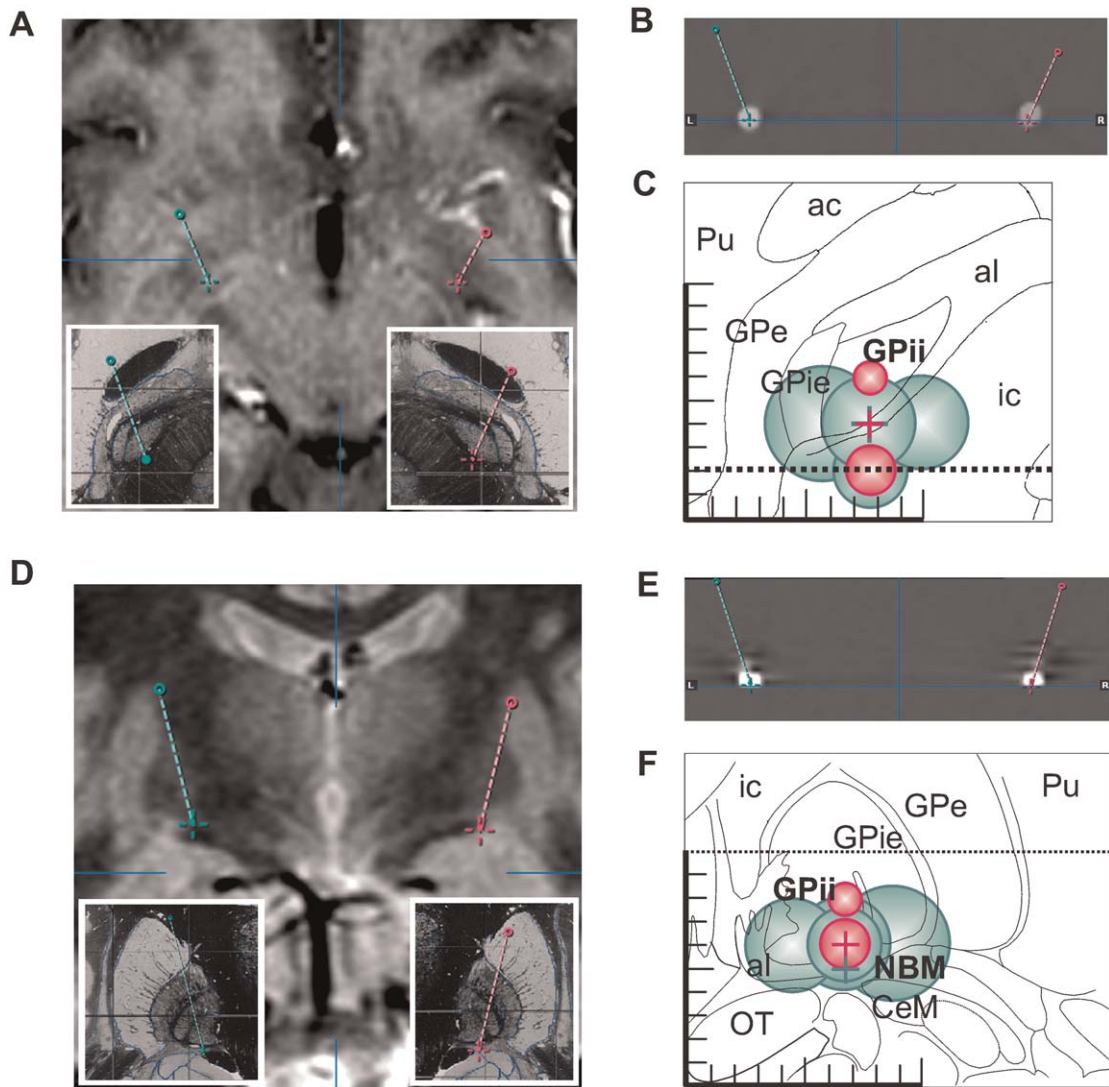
Stereotactic reconstruction. Stereotactic reconstruction of stimulation sites in the horizontal (A–C) and frontal plane (D–F), respectively. (A) Horizontal T1-weighted MR section with planned target sites at the pallidal base. Insets show the trajectory superimposed on corresponding horizontal sections of the Schaltenbrand/Bailey atlas (Schaltenbrand and Bailey, 1959). (B) Planned trajectory superimposed on a postoperatively acquired horizontal stereotactic CT scan. Note the correspondence with the artefact derived from the implanted DBS electrode. (C) Reconstruction of peripallidal stimulation sites that led to behavioural arousal, with the assumed radial current spread superimposed on a corresponding horizontal atlas section. Note that stimulation results from both hemispheres are superimposed (dark grey, left hemisphere [red in the web version]; light grey, right hemisphere [green in the web version]). Scale bar is 10 mm. Dotted line indicates the midcommissural level. Abbreviations: ac, anterior commissure; al, ansa lenticularis; NBM, ncl. basalis Meynert; CeM, centromedial amygdaloid nucleus; GPe, external pallidal segment; GPie, lateral part of the internal pallidal segment; GPii, medial part of the internal pallidal segment; ic, internal capsule; Pu, putamen. (D) Assumed trajectory course superimposed on a frontal T2-weighted MR section. Note the proximity of the target sites to the optic tract. Insets depict the stereotactic trajectory drawn on a corresponding frontal section of the stereotactic atlas of Schaltenbrand and Bailey (1959). (E) Postoperative stereotactic CT scan, frontal reconstruction. Confirmation of the correct placement of the DBS electrode through superposition of the planned trajectory on the electrode artefact. (F) Reconstruction of arousal-associated stimulation sites and assumed current spread in the frontal plane. Abbreviations as in panel C.
